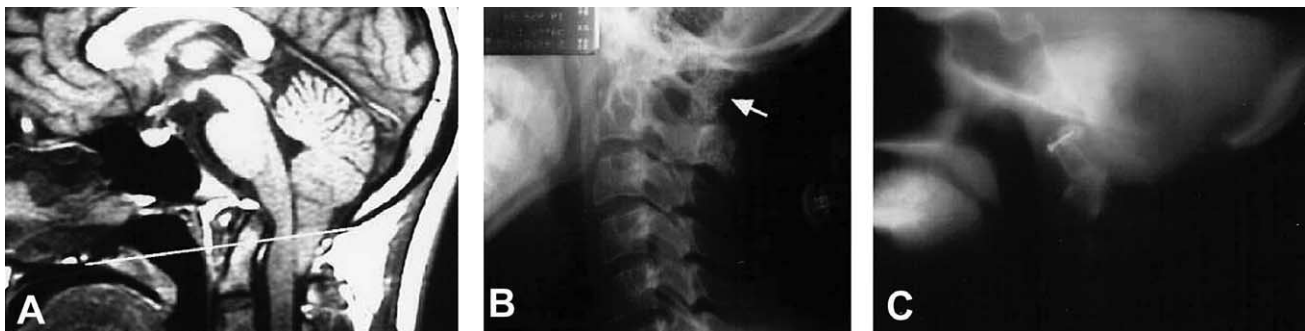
Case 2. A. Preoperative sagittal T1-weighted MRI showing compression of the medulla oblongata by an elongated odontoid process, associated with a Chiari malformation. The tip of the odontoid process is 10 mm above McGregor's line (white line). B. Postoperative plain x-ray after posterior decompression with a C1 laminectomy and fusion. Bone graft was placed between the occiput and C2 (arrow). C. Postoperative midsagittal tomogram after transoral odontoidectomy. A piece of iliac bone is inserted between the remaining rostral part of the C1 arch and the C2 body and fixed with mini-screws to the residual C1 arch.
